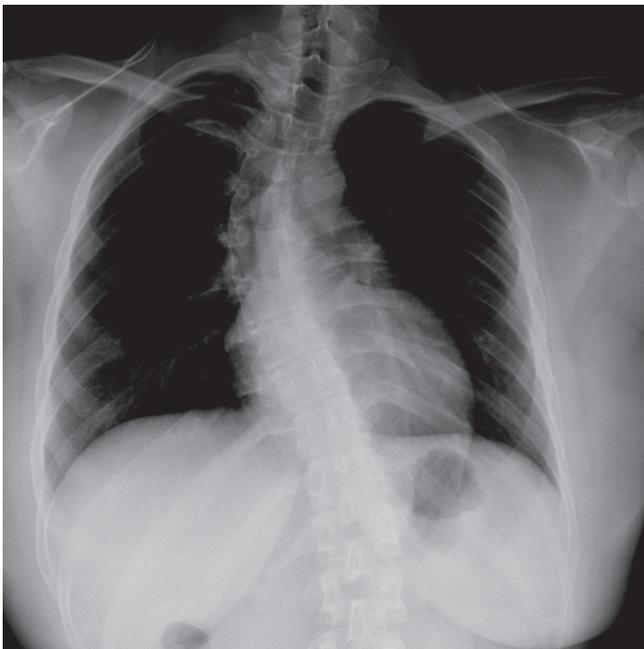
Chest X-ray show fixed scoliotic deformity. The major scoliosis is concentrated in the thoracic region and curves to the right.
